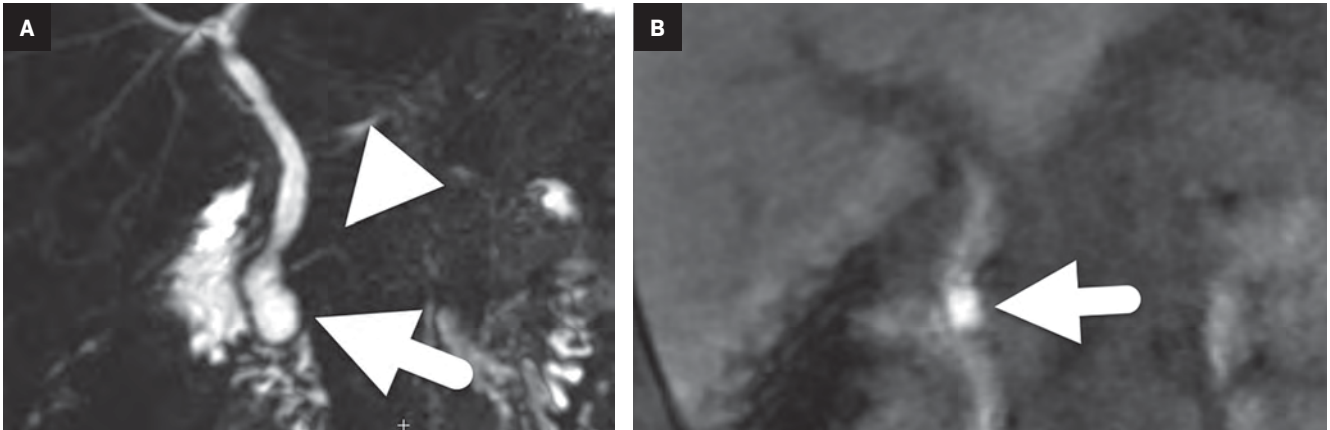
Coronal T2 MRI performed five years later shows the cystocele (arrow) extending into the duodenal lumen. The common bile duct is dilated..
